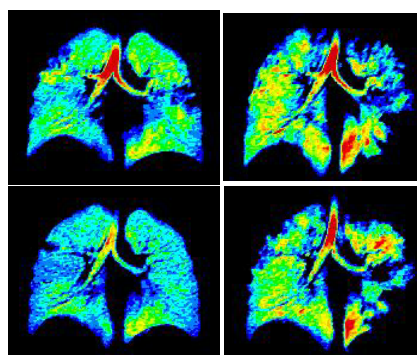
^3He MRI fractional ventilation maps at baseline (left column) and after Mch challenge (right column), at day 1 (top row) and day 2, 45 days later (bottom row).
